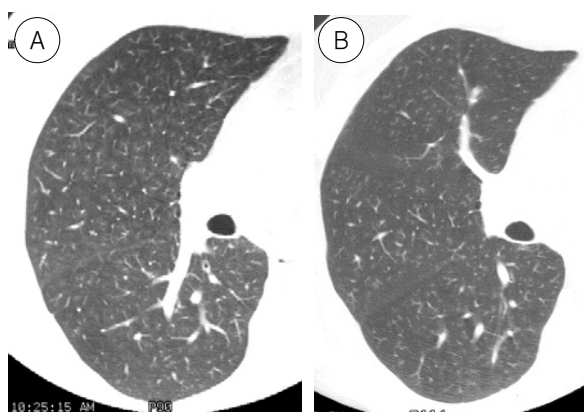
Respiratory bronchiolitis-associated interstitial lung disease in a 43-year-old woman. (A) Initial HRCT scan at level of bronchus intermedius shows extensive ground glass opacity and centrilobular nodules with bronchial wall thickening. (B) After 5 months of cessation of smoking, the follow up CT scan at similar level shows much decreased extent of ground glass opacity and centrilobular nodules.
